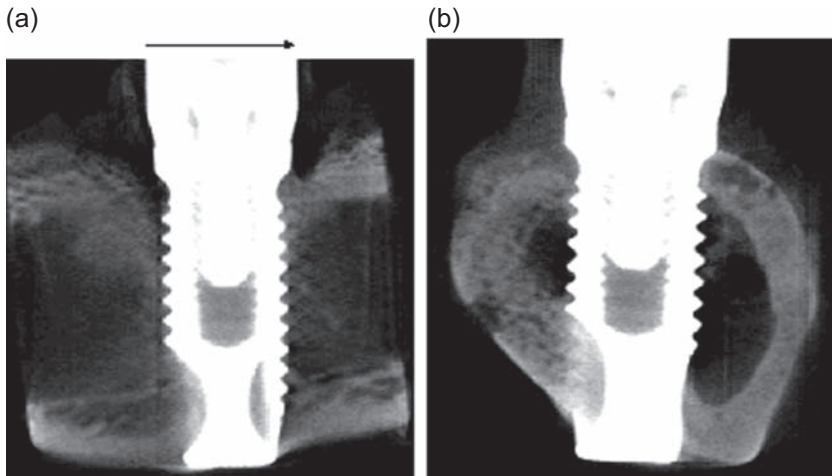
Two-dimensional microcomputed tomography image of a dynamically loaded implant, parallel (a) and perpendicular (b) to the long axis of the tibia. The *arrow* indicates the load direction [75].
